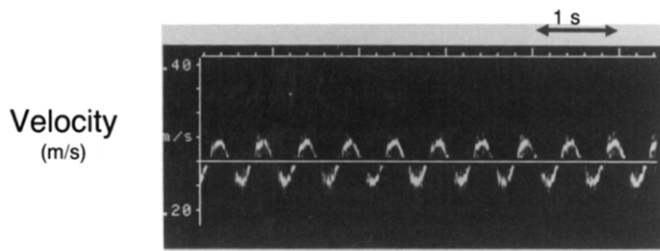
Doppler signal derived from the motion of the tubing. The cornstarch-water slurry is within the tubing but is not being pumped. The Doppler signal is generated entirely by the motion of the tubing, reflected by the cornstarch-water slurry.
